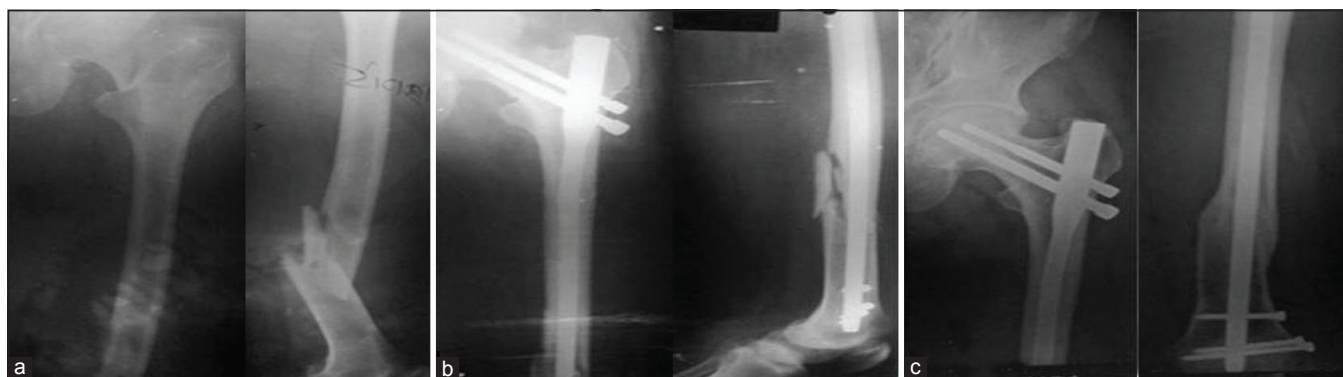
X-ray of shaft femur with hip joint (anteroposterior and lateral views) showing (a) Intracapsular fracture neck femur with shaft (b) 10 days postoperative (c) 10 months after followup healing of both the fractures
